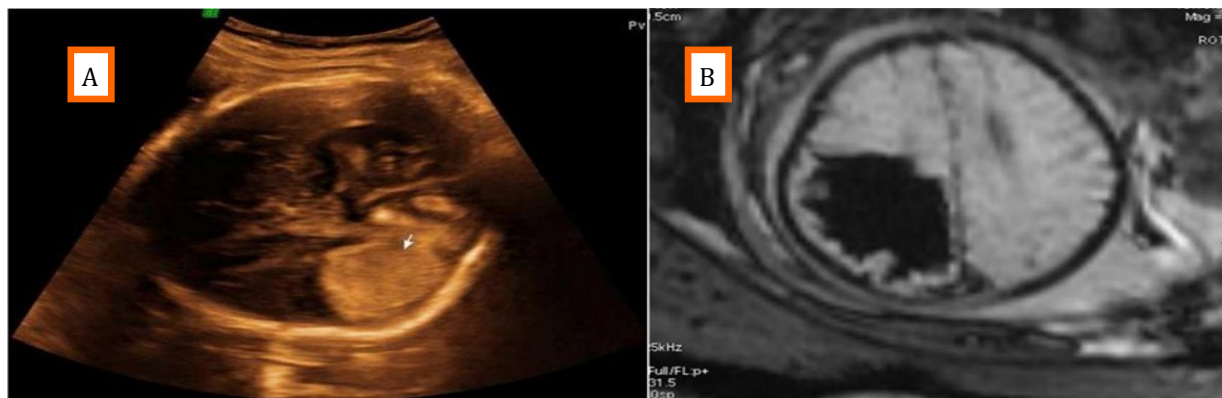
A. Foetal sonogram at 37 weeks of gestation. B. MRI showing intraparenchymal haemorrhage in the left paratrigonal, temporo-parieto-occipital regions with extension into the ventricles, basal cisterns and sulcal spaces.
